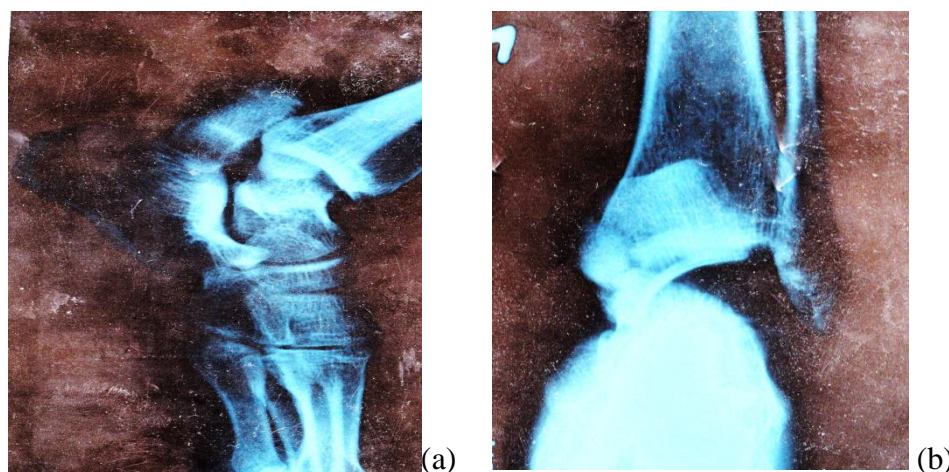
preoperative radiograph Anteroposterior & Lateral
